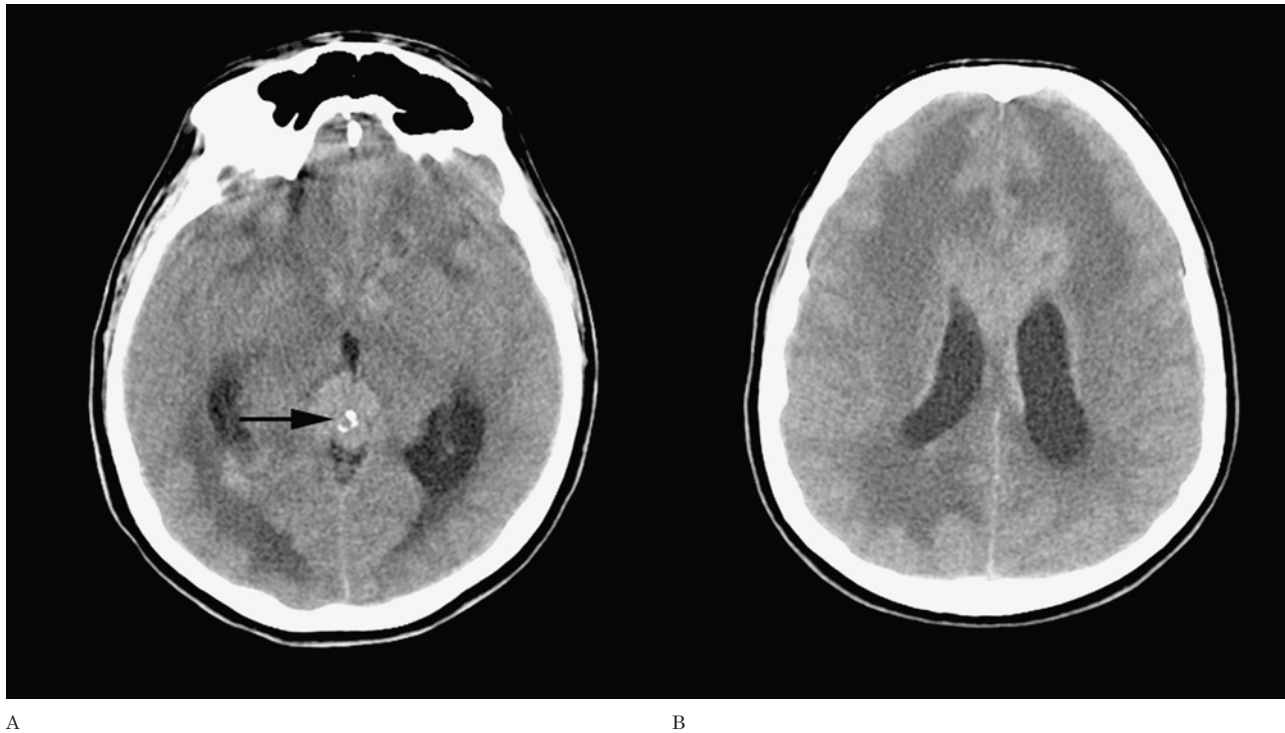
Germinoma. A) Non-contrast CT shows a mass centred in the pineal region, which characteristically 'engulfs' the calcifications (arrow) within the pineal gland. The mass extends anteriorly as a midline mass between the lateral ventricles. Prominent vasogenic oedema is noted surrounding the tumour (A,B). Strong, homogenous enhancement is seen on enhanced T1W axial MR images (C,D).
